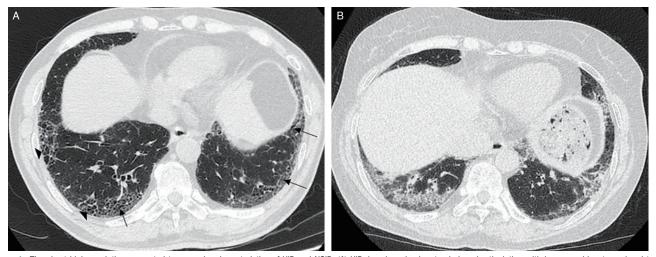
The chest high-resolution computed tomography characteristics of UIP and NSIP. (A) UIP: basal predominant subpleural reticulation with honeycombing (arrowheads) and traction bronchiectasis (arrows). (B) NSIP: interlobular septal thickening with subpleural GGO and the absence of honeycombing. GGO: Ground glass opacities; NSIP: Non-specific interstitial pneumonia; UIP: Usual interstitial pneumonia.
